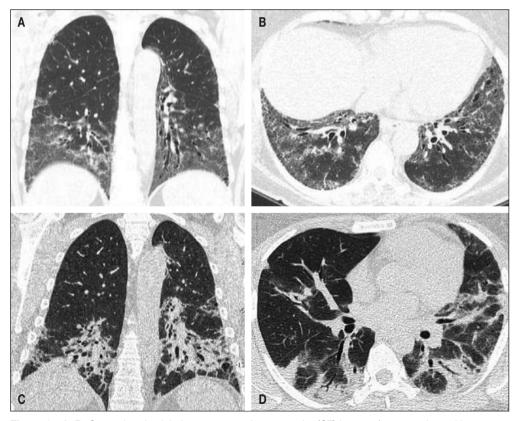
A, B: Coronal and axial chest computed tomography (CT) images from a patient with nonspecific interstitial pneumonia associated with antisynthetase syndrome show bilateral and predominantly lower lobe ground-glass opacities and traction bronchiectasis; C, D: Coronal and axial chest CT images from a patient with polymyositis and organizing pneumonia demonstrate areas of consolidation in the lower lung lobes, predominantly peripheral and along the perobroncovascular axis.
